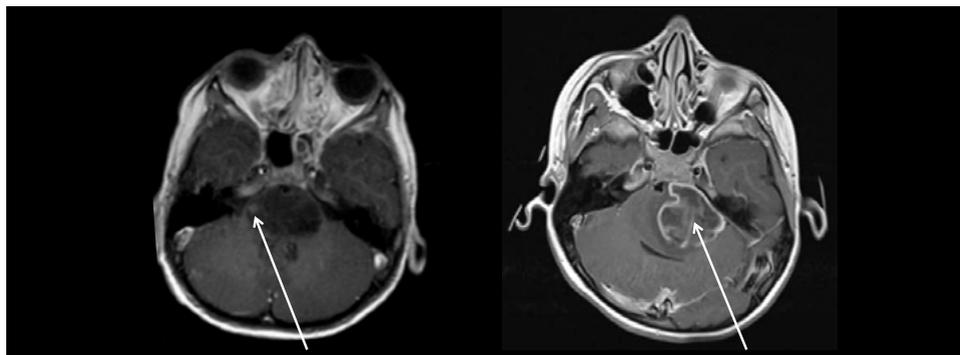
Two patients with DIPG who underwent T1-weighted MRI with contrast: (A) the tumor shows a small nodular enhancement (arrow) which was therefore not scored as ring enhancement; (B) the tumor shows a large area of ring enhancement (arrow).
